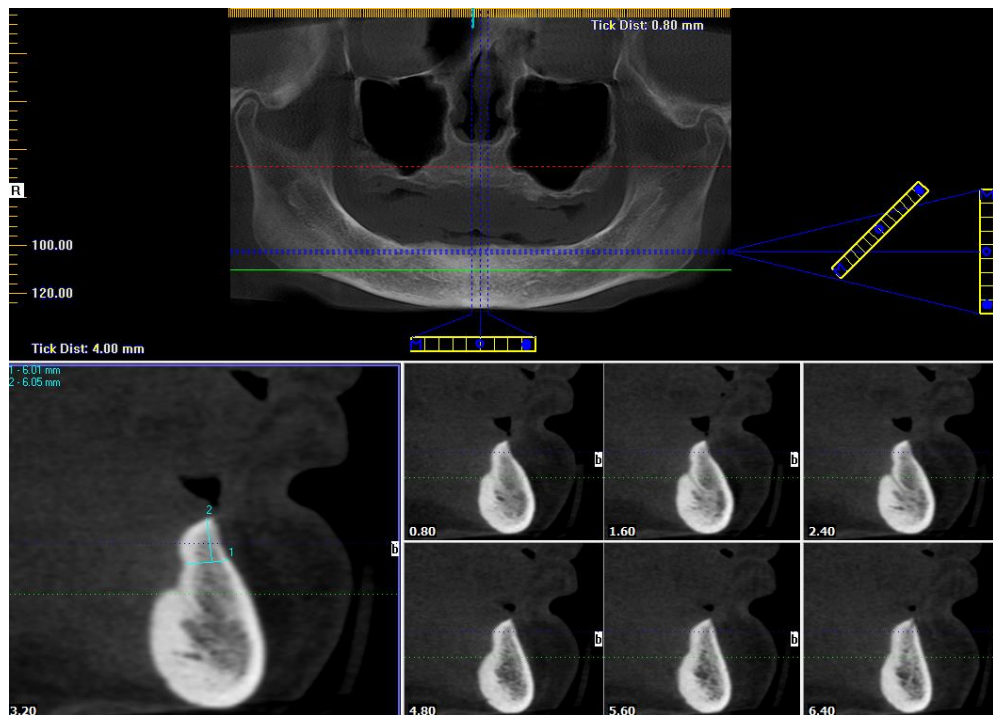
CBCT section showing “knife edge” ridge
